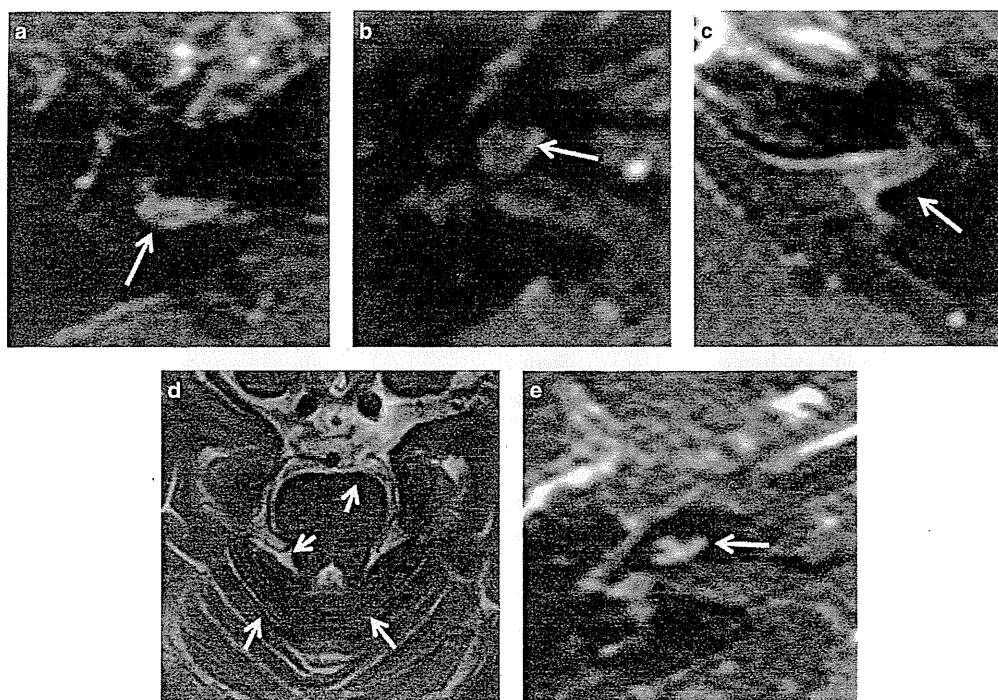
(a) Case no. 1. Cryptococcus meningitis with enhancement of bilateral internal auditory canal (IAC) on gadolinium-enhanced MRI. The enhanced right IAC is shown. (b) Case no. 2. Chronic viral meningitis plus labyrinthitis with enhancement of bilateral cochlea on gadolinium-enhanced MRI. The enhanced basal turn of the right cochlea is shown. (c) Case no. 3. Meningeal metastasis of lymphoma with enhancement of bilateral IAC on gadolinium-enhanced MRI. Enhanced left IAC is shown. (d) Case no. 4. Superficial siderosis with hypointensity along the brainstem and cerebellum on T2-weighted MRI. (e) Case no. 5. Cogan's syndrome with enhancement of bilateral cochlea on gadolinium-enhanced MRI. The right whole cochlea is enhanced.
